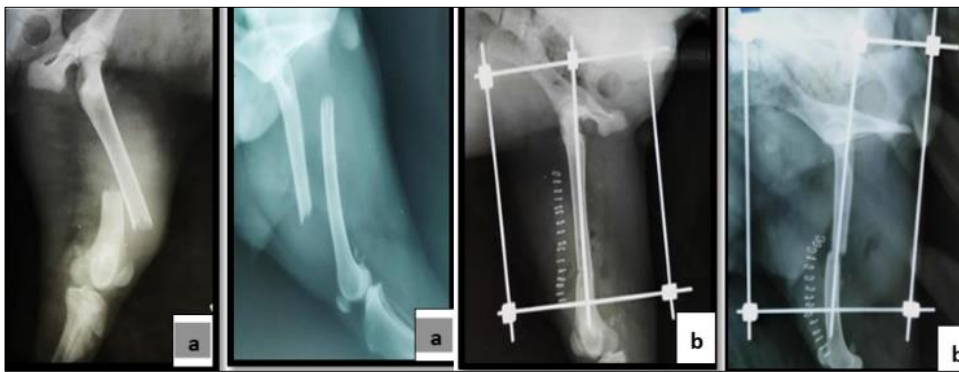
a) Pre-operative radiograph b) Immediate post-operative radiograph with IM+ESF tied-in configuration
